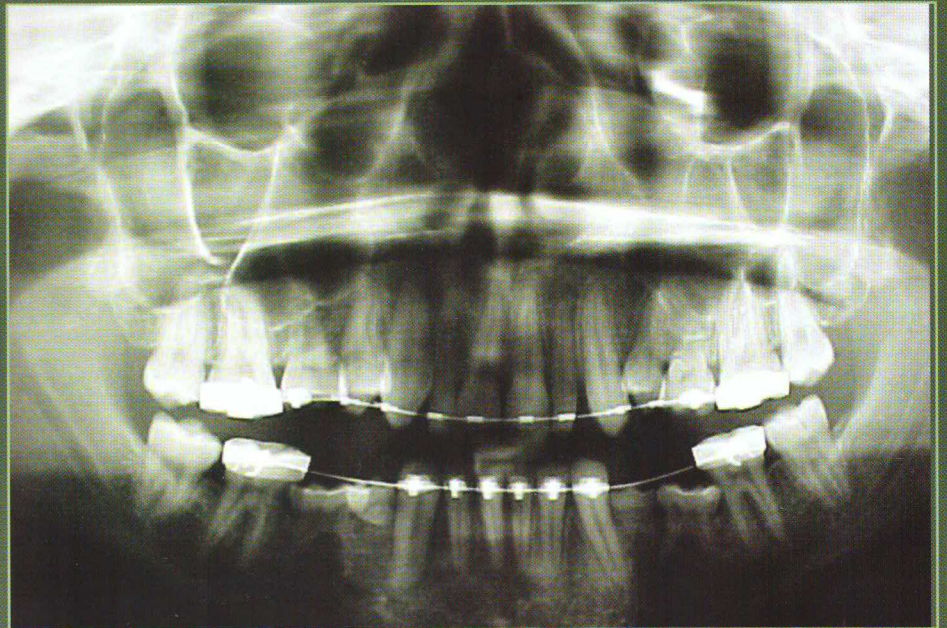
Radiographic view of submerged teeth
